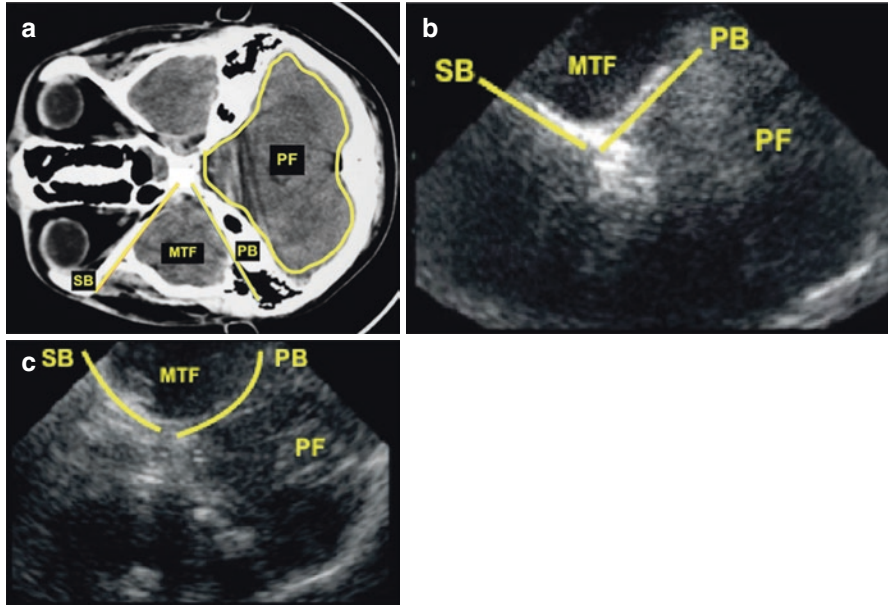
(a) Non-contrast CT brain-scan; (b) Lower pons plane: TCCS by transtemporal acoustic window; (c) Upper pons plane: TCCS by transtemporal acoustic window. (SB) Sphenoidal bone, (PB) Petrosal bone, (MTF) Middle temporal fossa and, (PF) Posterior fossa (cerebellum)
